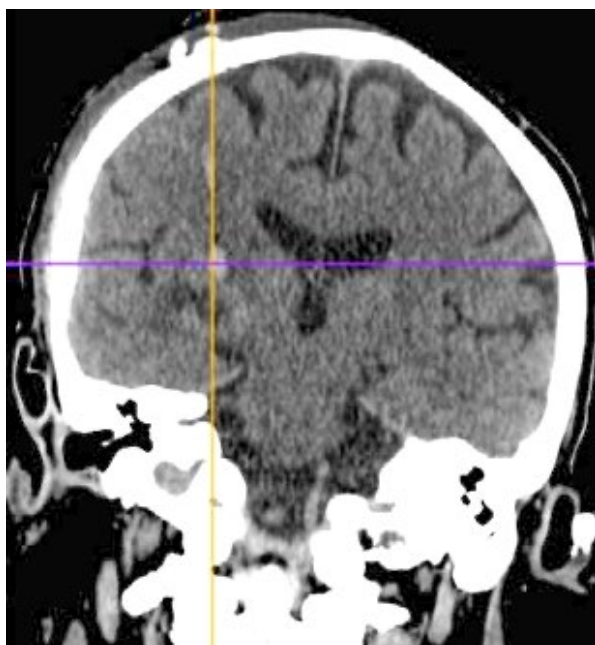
X-ray CT neuroimaging of postoperative, clinically insignificant microbleeding in the area of biopsy material withdrawal
